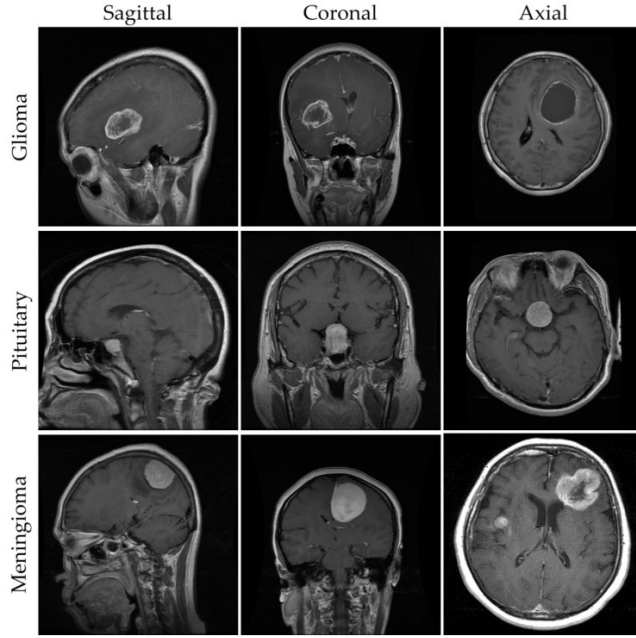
Sagittal, Coronal, and Axial views of a sample of MRI images of three different types of brain tumor [1]
